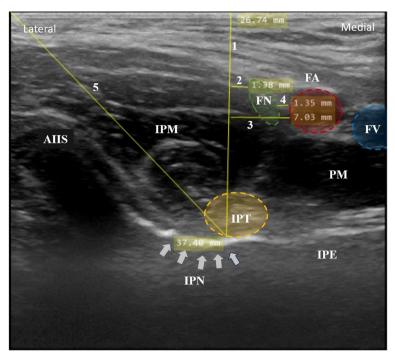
Ultrasound image of a 11-year-old girl 32 kg in weight and 138 cm in height. The distance between; 1: the iliopsoas notch and the reference line, 2: the femoral nerve and the reference line, 3: the femoral artery and the reference line, 4: the femoral artery and the femoral nerve, 5: the iliopsoas notch and the most lateral corner of the probe. White arrows indicate the iliopsoas notch. FA: femoral artery, FN: femoral nerve, FV: femoral vein, IPE: iliopubic eminence, IPM: iliopsoas muscle, IPN: iliopsoas notch, IPT: iliopsoas tendon, PM: pectineus muscle, AllS: anterior inferior iliac spine
